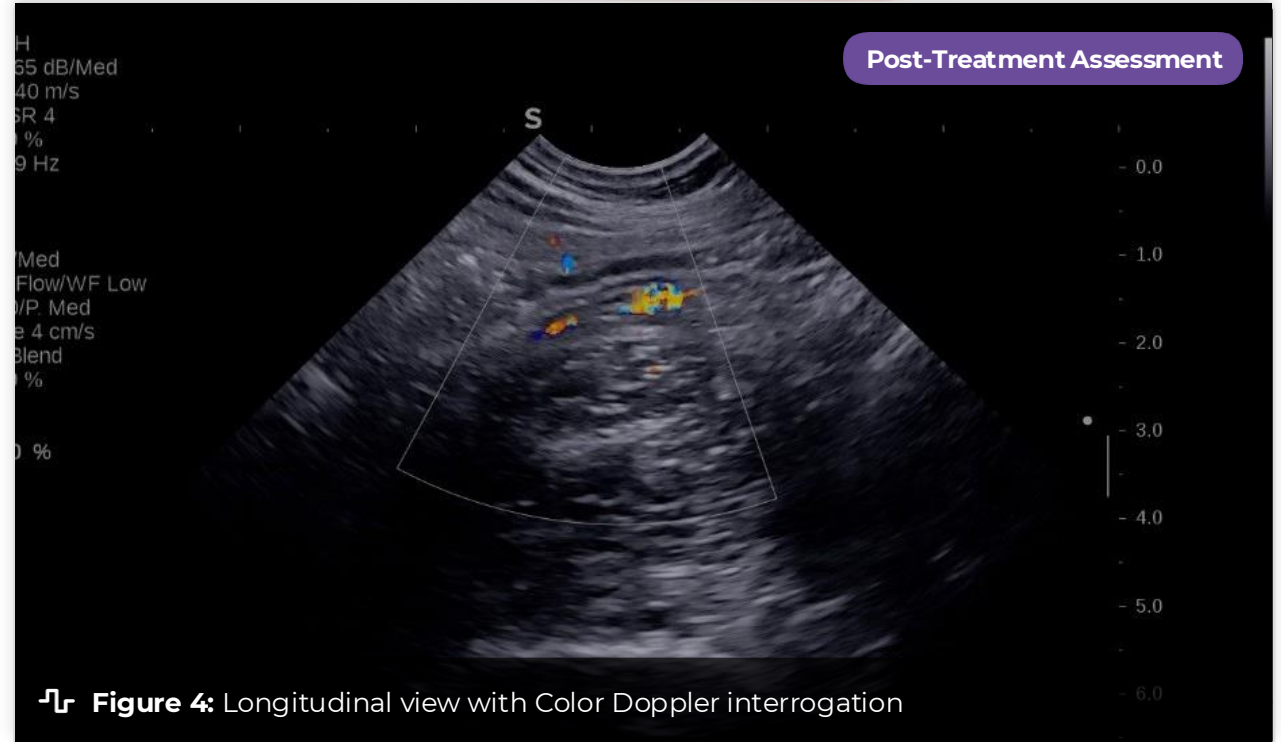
Longitudinal view with Color Doppler interrogation
